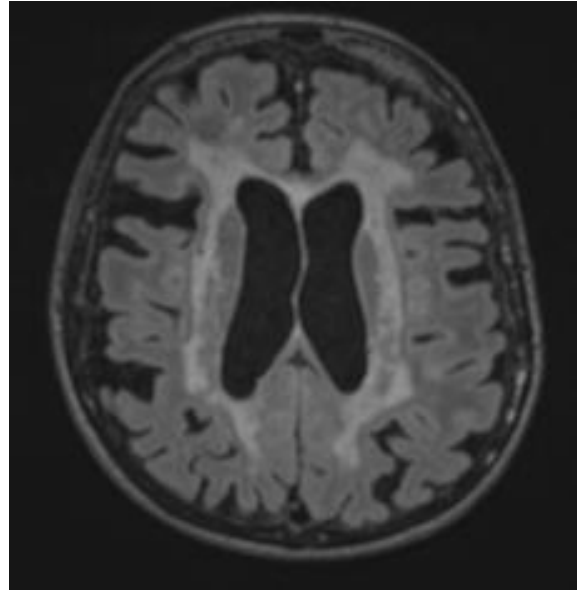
depicts examples of brain scan images of microbleeds, WMH, and lacunes, using different MRI-sequences. Photo 2 of figure 2 depicts WMH of 3 on Fazekas scale. The scale classifies the white matter into periventricular white matter and deep white matter, with the grade depending on the size and the confluence of lesions. The scale ranges from 0 to 3, with 3 being the most severe, indicating irregular periventricular signal extending into the deep
